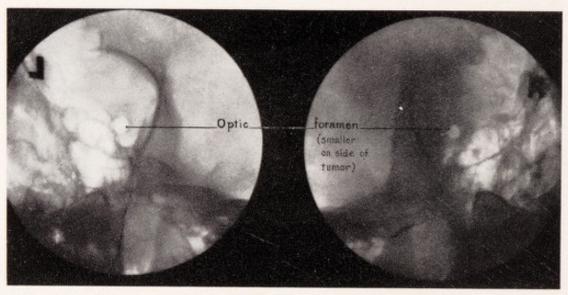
Case 19. Retouched X-ray showing reduction in size of optic foramen on tumor side.
